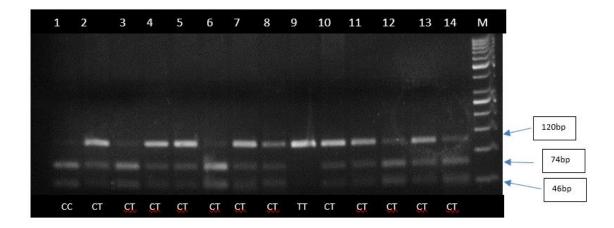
4% agarose gel visualization of TGF- β RFLP in HIV samples. Product size for TT genotype of TGF- β : 120bp respectively. Product size for CT genotype of TGF- β : 120bp, 74bp & 46bp, respectively. Product size for CC genotype of TGF- β : 74bp & 46bp respectively M: 50bp Ladder.
